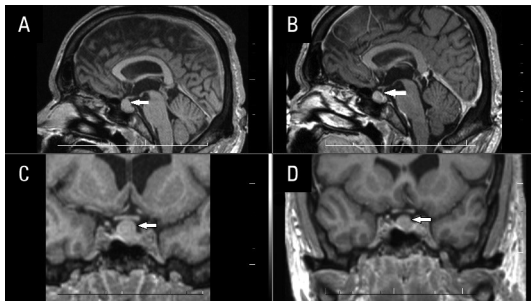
Pituitary magnetic resonance imaging (MRI). A. T1VO in sagittal axis — on admission; B. T1VO in sagittal axis — after 1 year under treatment with somatostatin analogues; C. T1VO in transversal axis — on admission; D. T1VO in transversal axis — after 1 year under treatment with a somatostatin analogues. The white arrow marks pituitary adenoma
